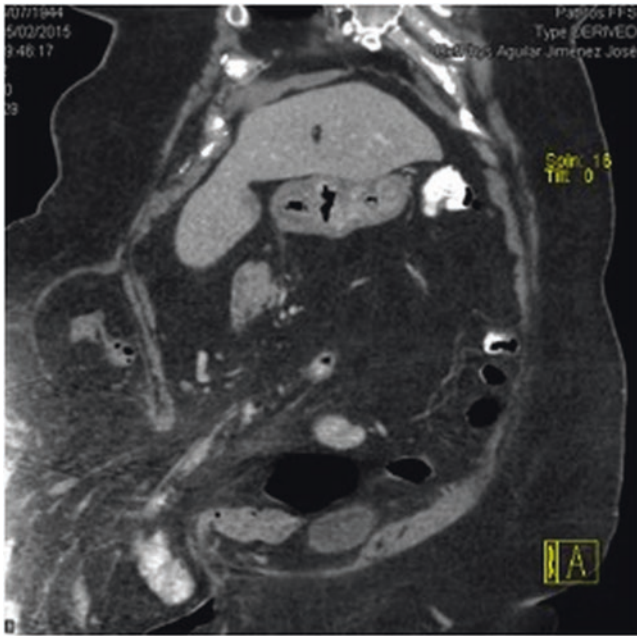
CT: Iliac hernia
